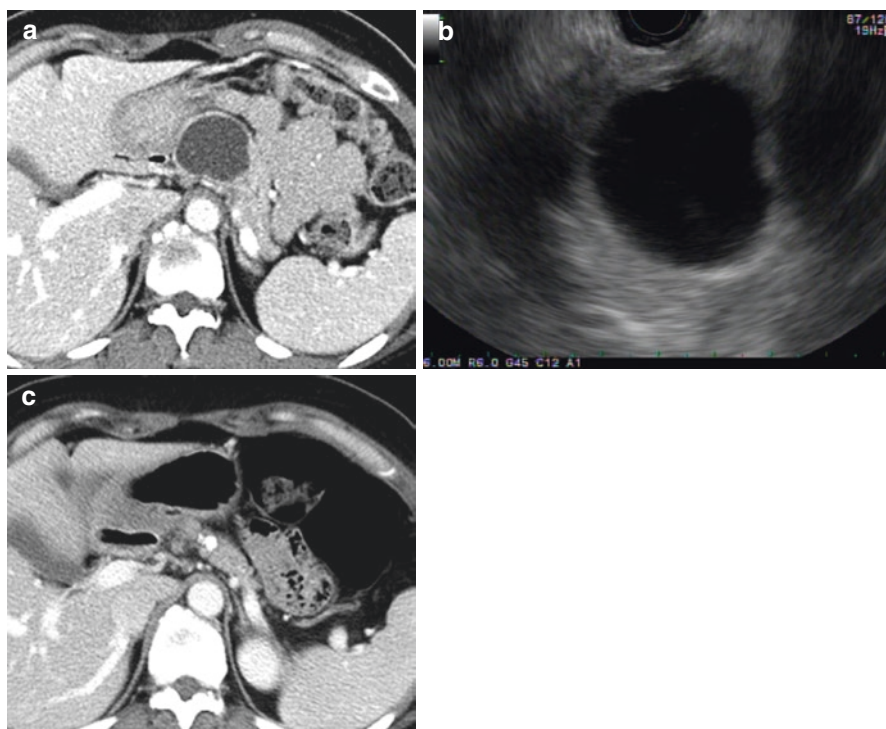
(a, b) A 36-mm unilocular cyst in the body of the pancreas. (c) Dense calcification replaced the original cyst on follow-up CT scan at 30 months after cyst ablation (Reprinted from *Gastrointestinal Endoscopy*, Volume 77 (4), Hyung-Chul Oh and William R Brugge, EUS-guided pancreatic cyst ablation: a critical review (with video), 526–533, 2015, with permission from Elsevier)
